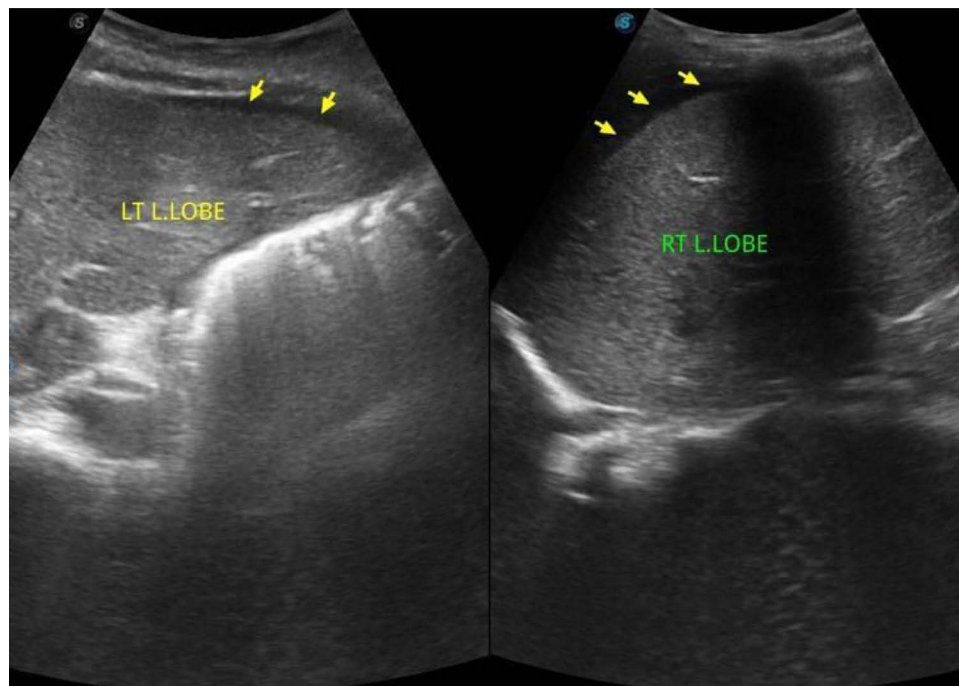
Follow-up ultrasound showed mild ascites, the yellow arrow indicates ascites.
